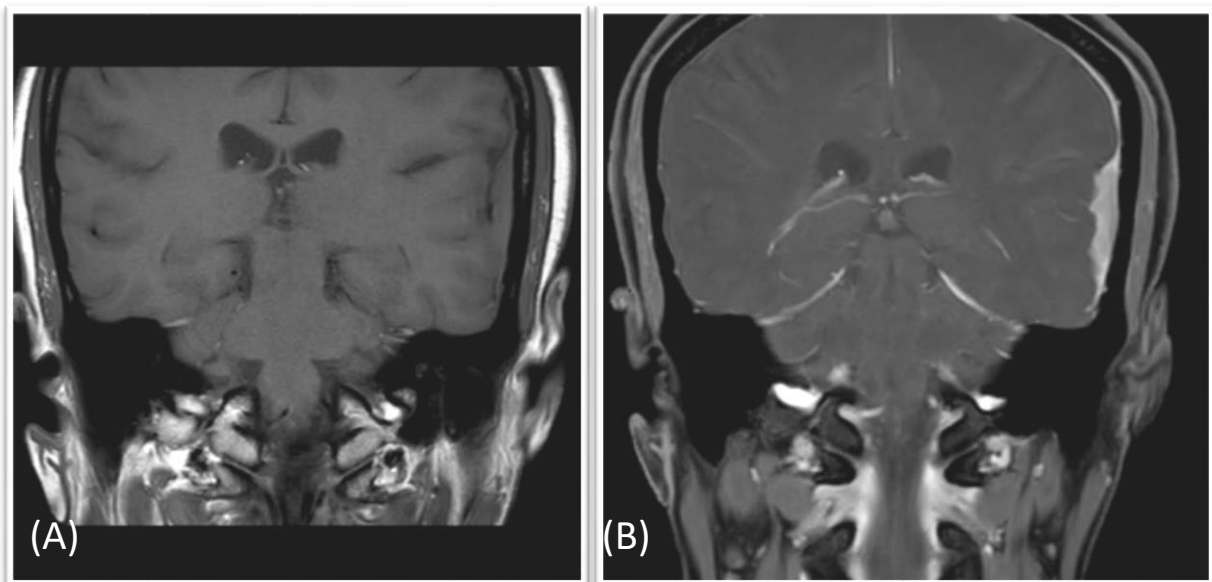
MRI Brain A (plain) & B (contrast), coronal sections showing enhanced meninges
